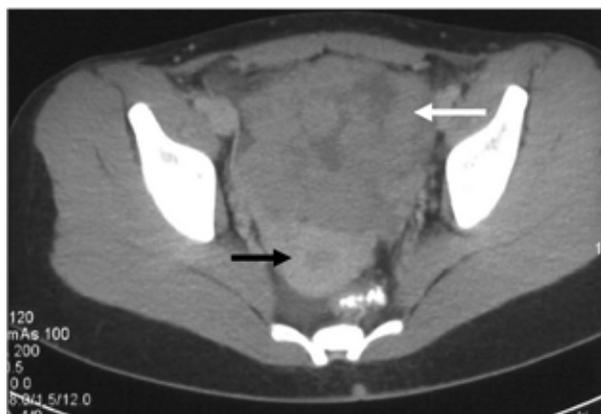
CT scan of the pelvis revealing a multilobulated mass (white arrow) in a 17-year-old girl. The mass is separate from the uterus (black arrow). Contrast is seen in the rectum. Final pathology revealed a dysgerminoma.
